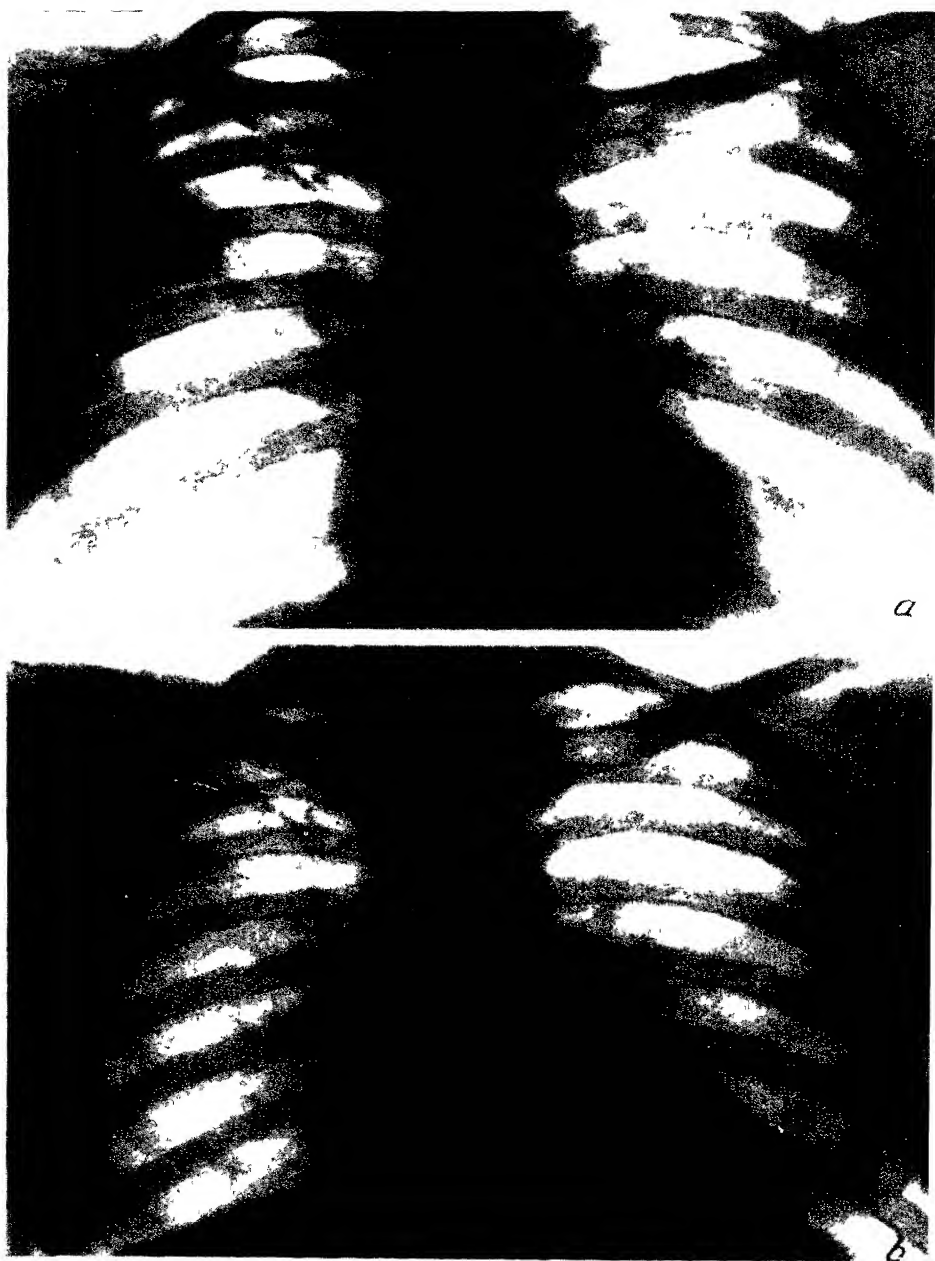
Lung X-rays of patient S
